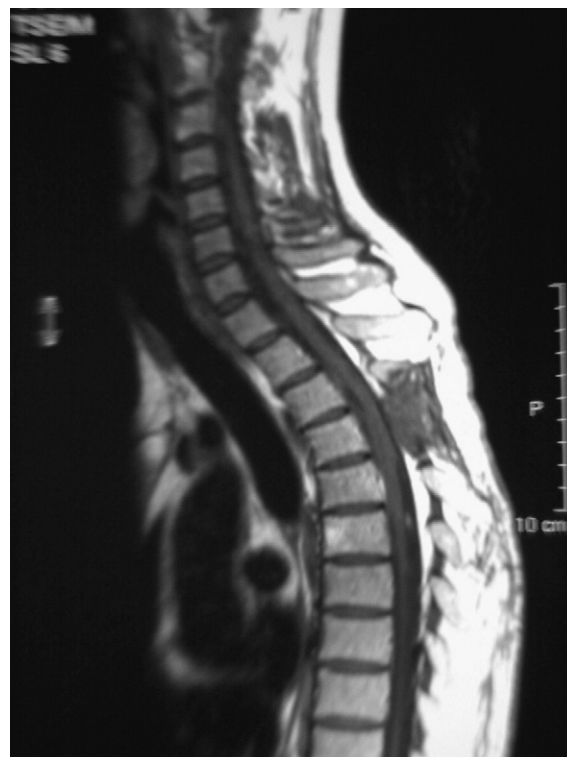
Sagittal MR imaging of a patient taken 4 years after MSCs implantation.
